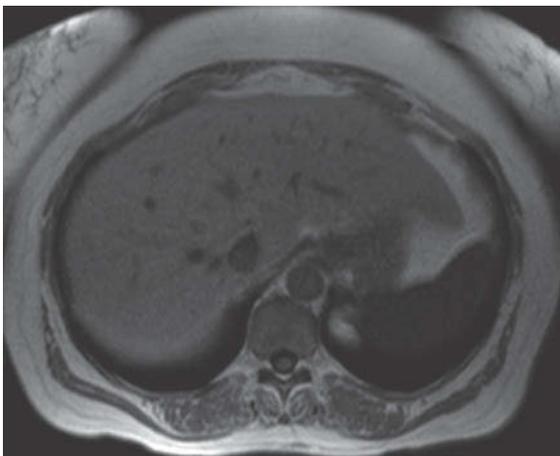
Focal fatty infiltration. Axial contrast-enhanced CT (A) in a patient with known lung cancer demonstrates multiple, small low-attenuation lesions within the liver (arrow). Axial out-of-phase image (B) demonstrates dramatic signal loss of many of these lesions (arrow) compared to in-phase image (C). This is diagnostic of nodular, focal fatty infiltration – *not* metastatic disease.
